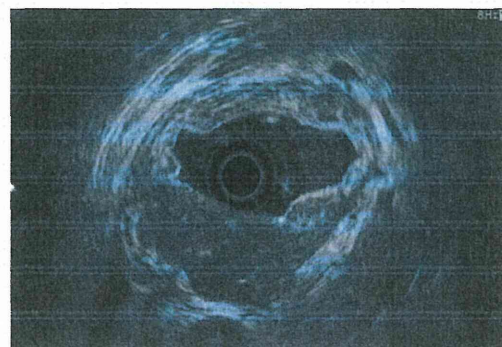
Endoscopic ultrasound shows submucosa of gastric wall is predominantly thickened.
